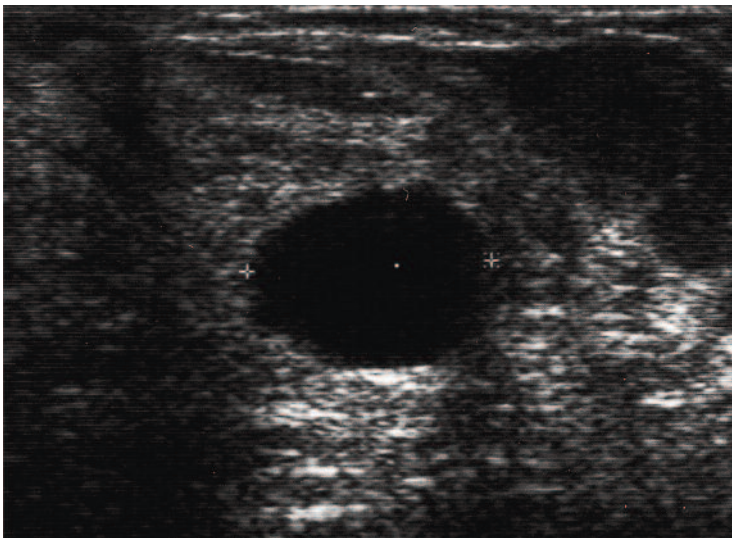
(above). Targeted ultrasound imaging of a clinical lump has identified a normal cyst.
